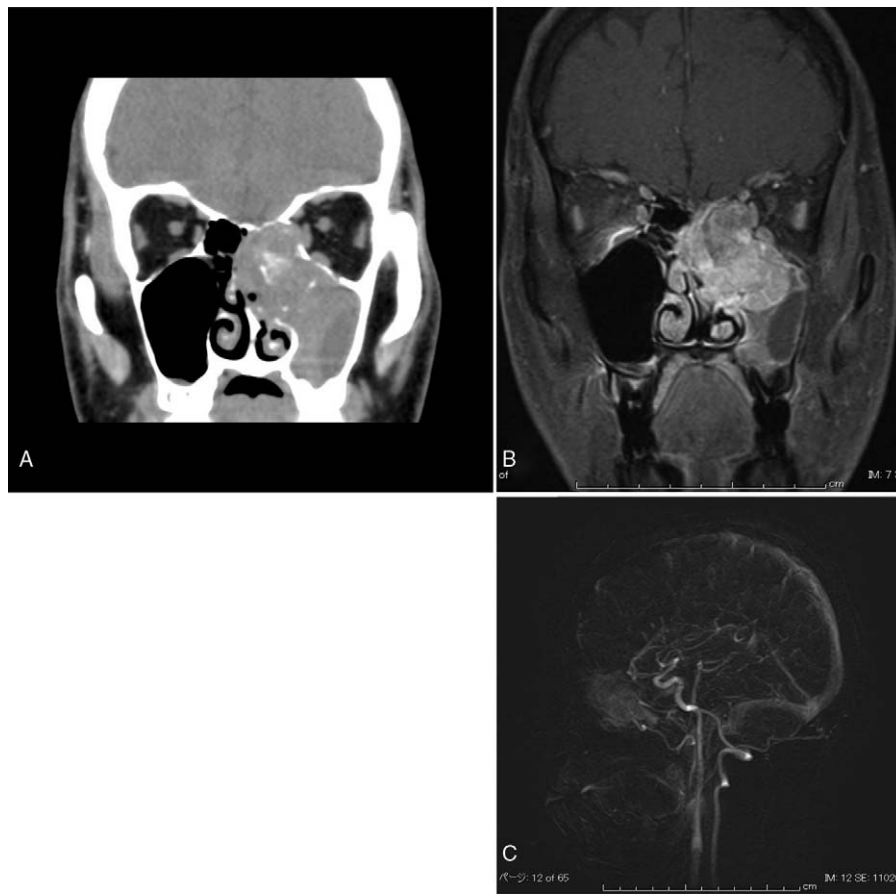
Image of the patient's tumor. (A) A coronal CT image revealed an expansive nasal mass in the patient's left ethmoid sinus that had calcification extending into his maxillary sinus. The cribriform plate, orbit, and nasal septum were not involved. (B) A coronal MRI of the patient's brain and nasal and paranasal cavities showed an enhanced image of the tumor in the left ethmoid sinus. (C) MR angiography of the patient's sinus showing the maxillary artery (arrow) feeding the paranasal cancer (arrowhead).
